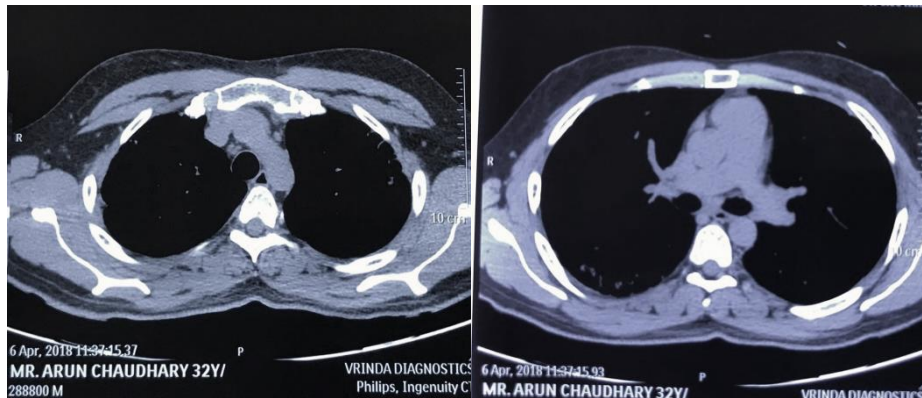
High-resolution CT scan (mediastinal window) shows calcified pleural plaques on the right side with adjacent diffuse pleural thickening on both sides.
